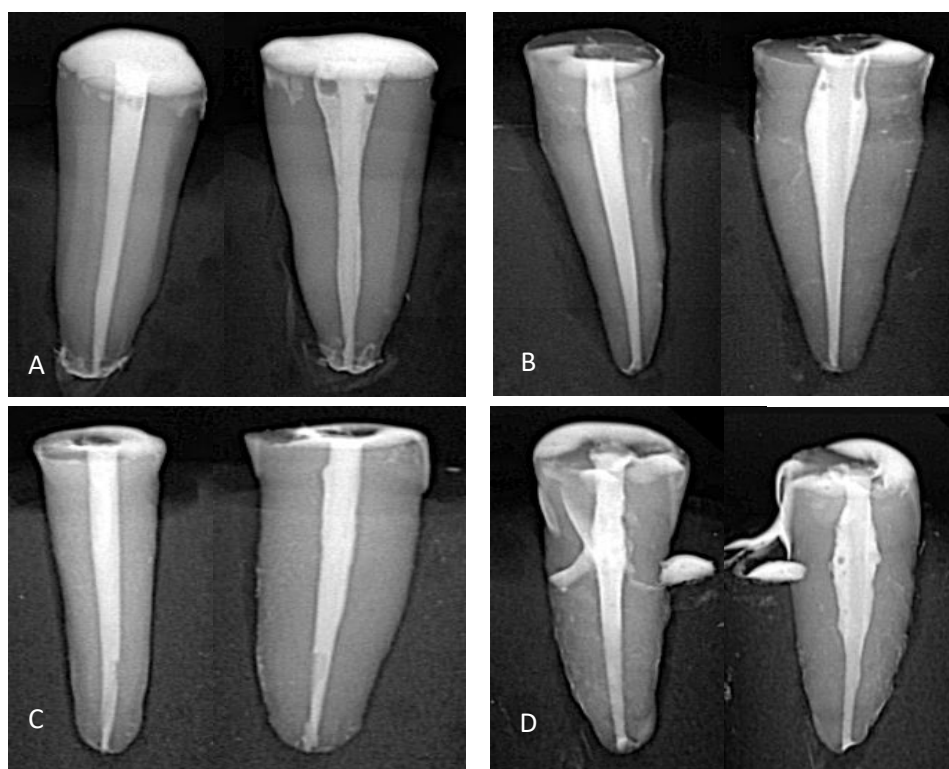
Samples of radiographic evaluation of root canal obturation. A: Conventional syringe irrigation with distilled water. B: Conventional syringe irrigation with NaOCl and EDTA. C: Sonic-activated irrigation with EndoActivator. D: Laser-activated irrigation with Er-Cr: YSGG.
